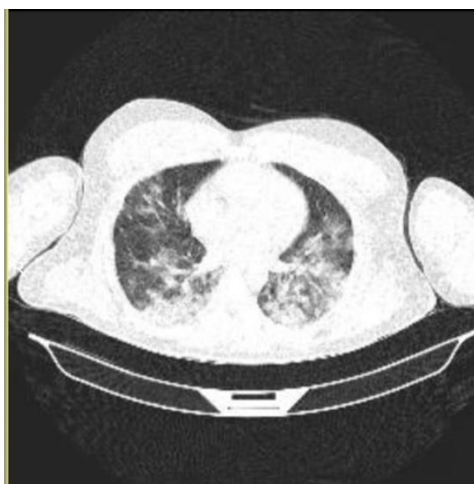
HRCT Showing ground glass opacities
